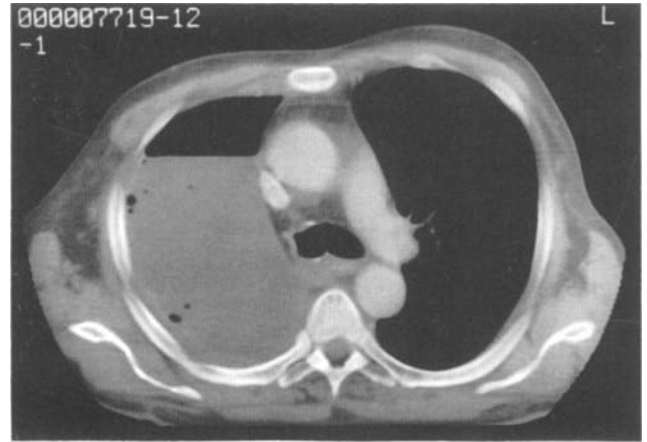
CT-scan without evidence of gross disease 12 months after extrapleural pneumonectomy and intraoperative mTHPC-PDT for malignant mesothelioma.
